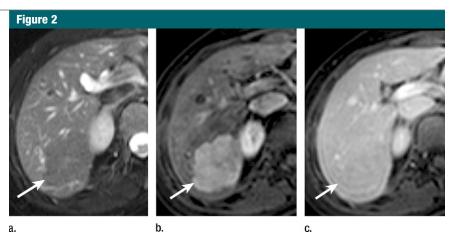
FNH incidentally discovered in an asymptomatic 32-year-old woman. Axial (a) T2-weighted (repetition time msec/echo time msec, 1800/85; 6-mm section thickness) and (b, c) gadolinium-enhanced T1-weighted (3.62/1.73; 5-mm section thickness) (b) hepatic arterial phase and (c) portal venous phase MR images show typical imaging features. Lesion (arrow) is homogeneously hypointense with a central hyperintense scar on a, shows intense arterial enhancement on b, and becomes isointense to liver parenchyma on c.
